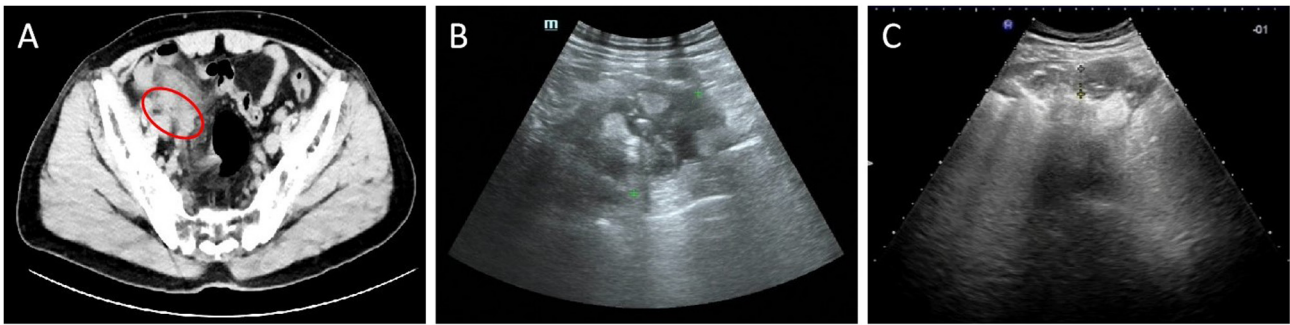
Abdomen CT and ultrasound examination, March 2023. (A) CT image showing oozing effusive changes in the iliac fossa area of the ileocecal region with adhesions to the adjacent bowel (red circle). (B) First ultrasound examination revealed disturbed intestinal echoes in the right lower abdominal region, mixed echoes were observed next to the iliac vessels, measuring ~6.5x5.3 cm, with tubular echoes, with a blind end on one side, and 1.6 cm at the widest point. Ultrasound suggested periappendiceal inflammatory wrapping. (C) Repeat ultrasound revealed mixed echoes in the iliac paravalses that were smaller than the previous echoes, measuring ~5.3x2.9 cm. m, m-type ultrasound mode.
